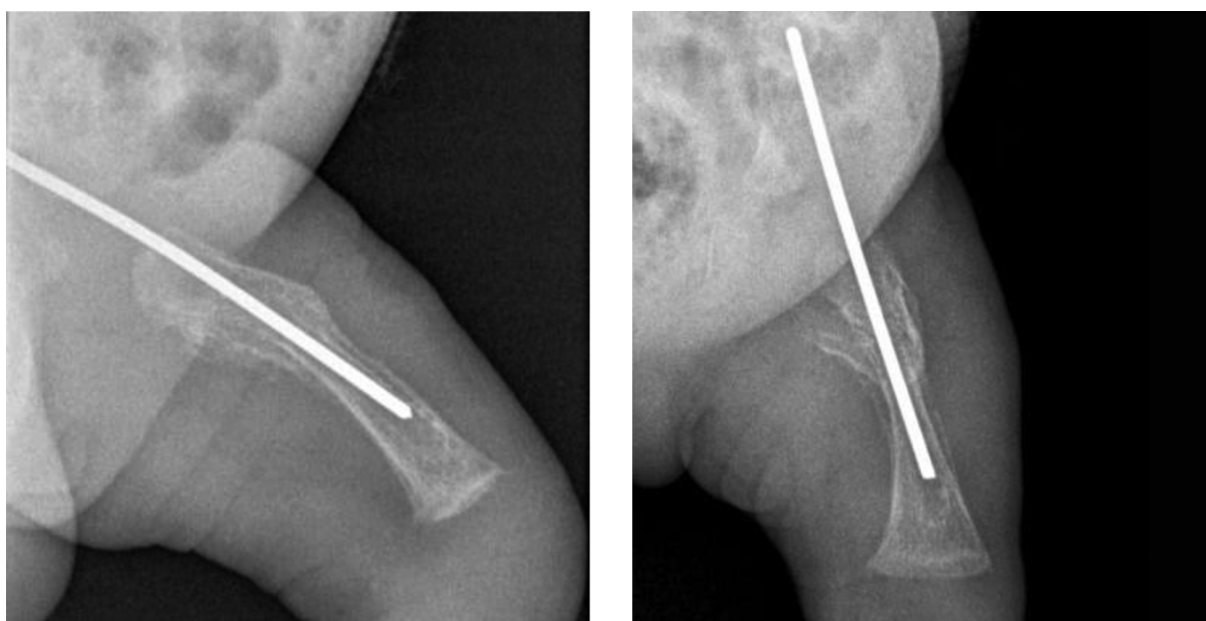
Radiograph Shows Healing After 6 Weeks
